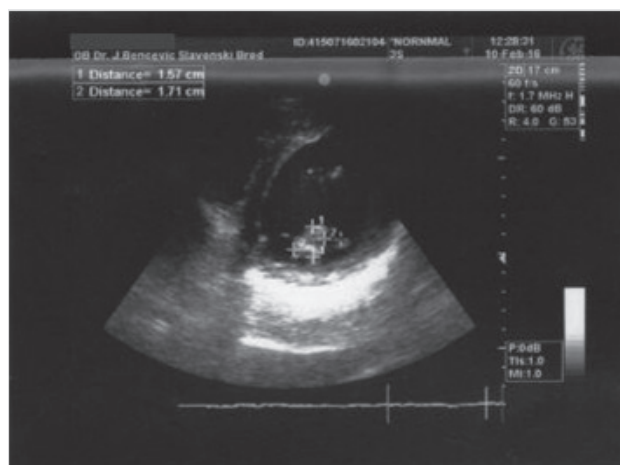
Echocardiography – thrombus in the left ventricle size 1.57x1.71 cm.
